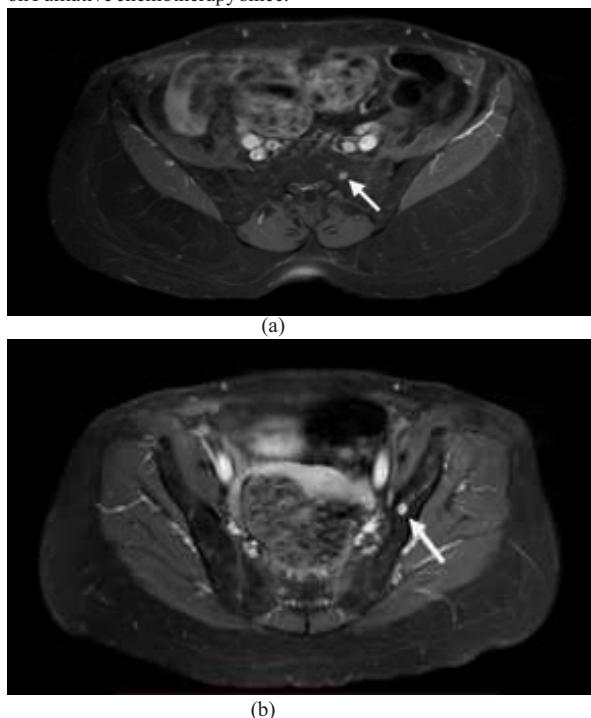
MRI Pelvis – axial sections showing T1 post-contrast hyperintense enhancing lesions (a) In the left ala of sacrum. (b) In the left iliac bone.
